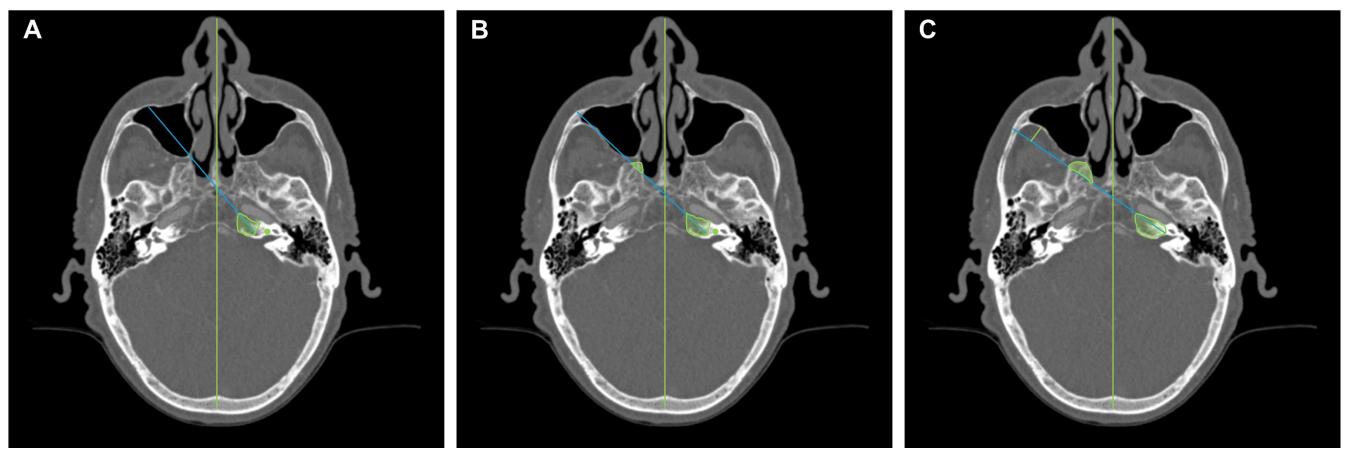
Radiographic measurements of computed tomography angiography (CTA) scans. (A) CTM approach highlighted in blue, with the target of the medial cochlea (green circle) taking care not to involve the pterygoid and ensuring no violation of the petrous carotid. Measurements include area of drilled retrocarotid petrous bone. (B) CTMP
